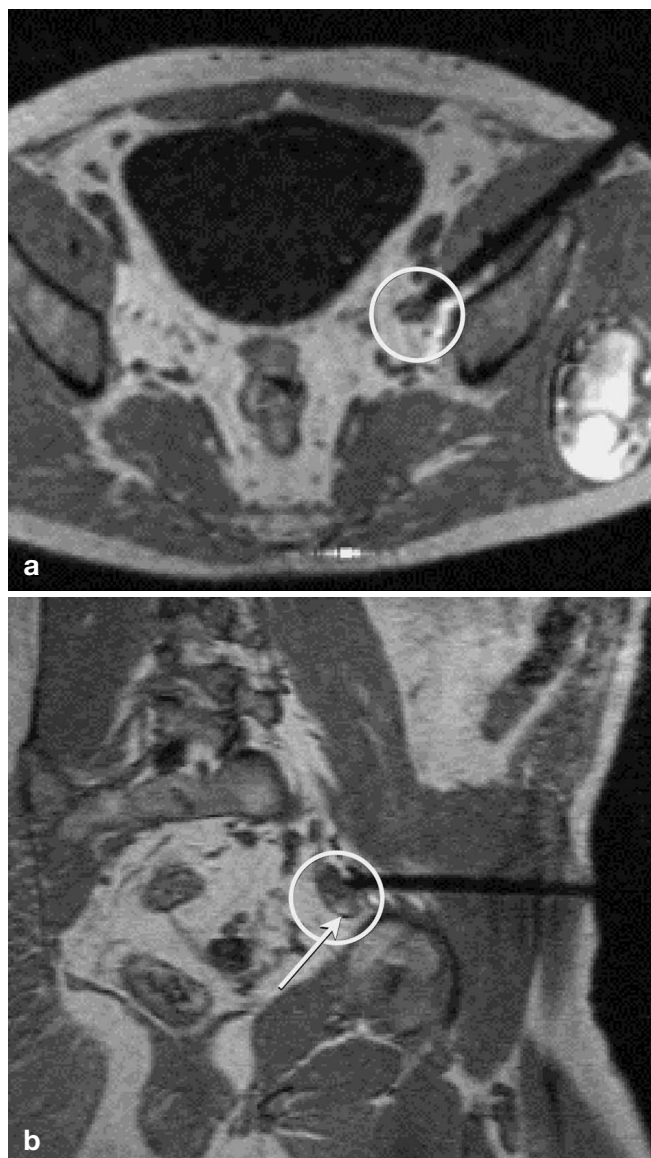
Magnetic-resonance-guided nodal biopsy. Patient with lymph node metastasis. a Axial and b semi-sagittal T1-weighted 3D MP-RAGE images during MR-guided biopsy. Needle is visible as black line. Tip of needle is situated at edge of enlarged node. In b internal structure of node can be recognized. A caudal small area of high signal intensity (arrow) represents fat in node. Biopsy at this site would have resulted in false-negative finding. Now needle was directed more cranial and biopsy was positive
